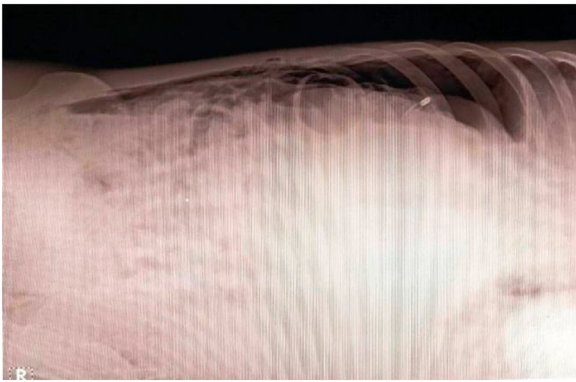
X-ray abdomen in left lateral decubitus position showing pneumoperitoneum.
